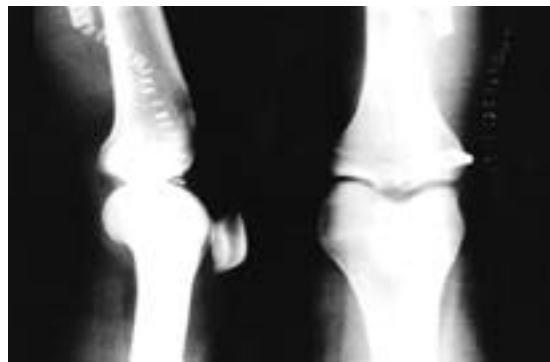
Postoperative plain radiographs following en block resection and fibula collateral ligament reconstruction with non absorbable suture and staple.
